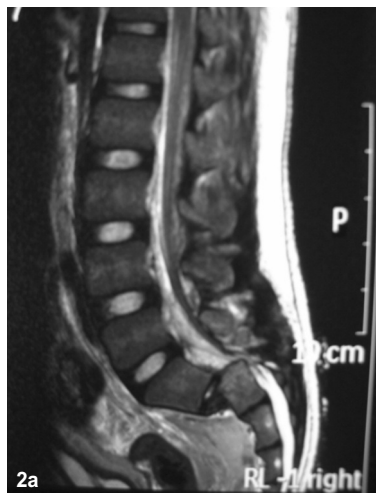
(a) T2-weighted MRI sagittal view showed dislocation of S1/S2 compressing the nerve roots; Figure 2(b) T2-weighted MRI axial view showing compression of traversing nerve roots.
